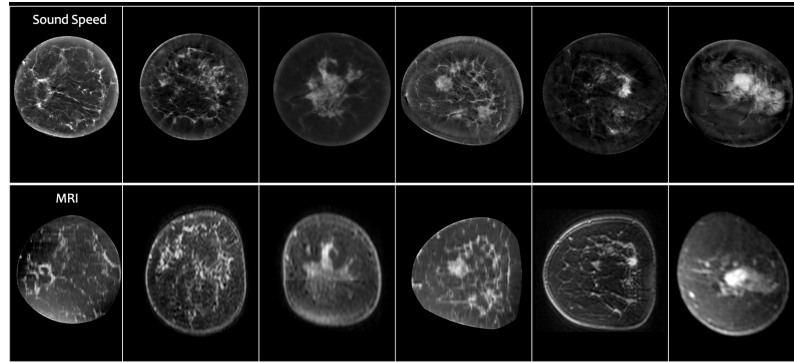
Comparison of coronal speed of sound and MRI slices of different patients for the Delphinus Softvue system. Speed of sound in the top row and MRI in the bottom row. Courtesy of Neb Duric, CTO, Delphinus Medical Technologies.
